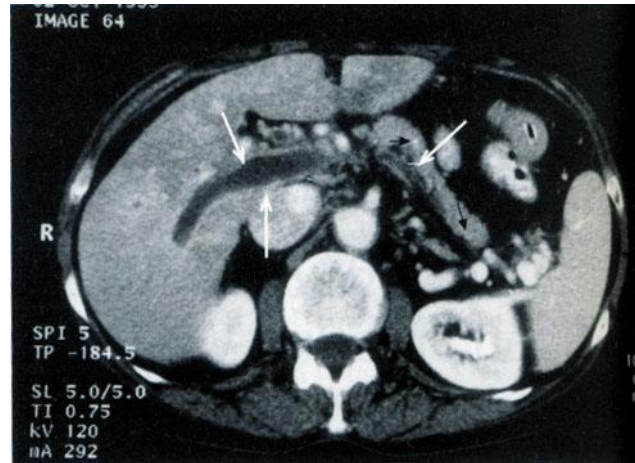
CT scan with intravenous contrast shows signs of thrombosis of portal and splenic vein in a patient with chronic pancreatitis. Because of thrombosis these veins are not contrasted (white arrows). A thin rim around the thrombus is defined, corresponding well-contrasted vascular wall. Black arrows indicate calcifications of the pancreas (according to P.A. Lipsett et al., 1998 [8]).
